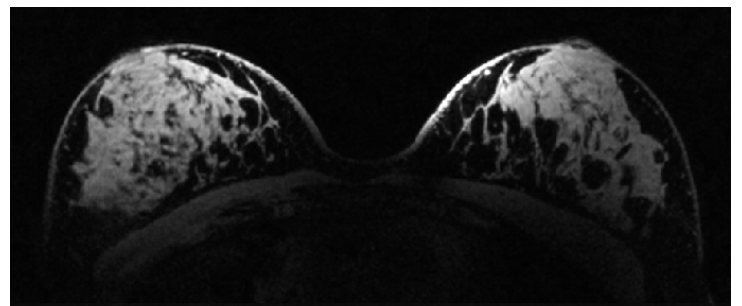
T1-weighted MRI obtained with an 1x1x2 mm³ acquired resolution in a patient with breast cancer (left, circle, temporal resolution 67s) and with an 0.5x0.7x0.7 mm³ acquired resolution in healthy volunteer (right), using a bilateral breast coil at 7T. Note the strong T1 weighting using a flip angle of 8 degrees and TR of 5.3ms (left, after injection of gadolinium) and superb fat suppression.
